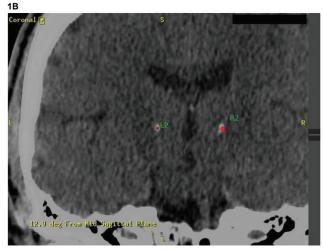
Imaging of Lead Placement. (A) Case 1. Preoperative magnetic resonance imaging and post-lead intraoperative computed tomography (CT) scan are co-registered using Medtronic FrameLink software. Targeted contacts are contact 1 on the left (L1) and contact 9 on the right (R2). On the left, the stereotactic error of contact 1 is 1.1 mm from the intended target (-14.25, 6.35, 0). On the right, the stereotactic error of contacts left, case(+), 1–, 3–; right, 11+, 9–, 10–). (B) Case 2. Intraoperative post-lead placement CT shows the position of contact 2 on the left ventralis intermedius (VIM) lead (L2), and contact 9 on the right VIM lead (R2). Contact 2 has a radial error of 0.9 mm off of the stereotactic plan targeting (-13.5, -6.75, 0). Contact 9 has a radial error of 0.7 mm off of the stereotactic plan targeting (13.5, -6.75, 0) (active contacts: left, case(+), 2–; right, 11+, 8–,10–; contact 9 is shown because it is between contacts 8 and 10.
